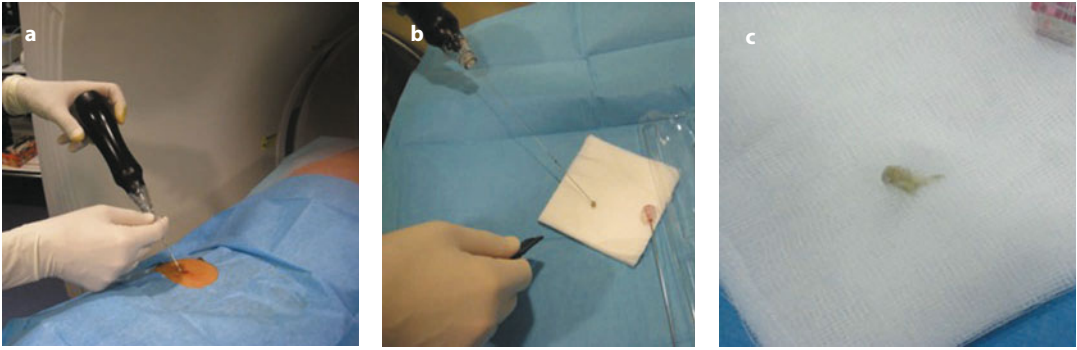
The decompressor percutaneous discectomy system under CT guidance (a) Removal of tissue from the herniated nucleus pulposus through the Dekompressor probe (b and c)
